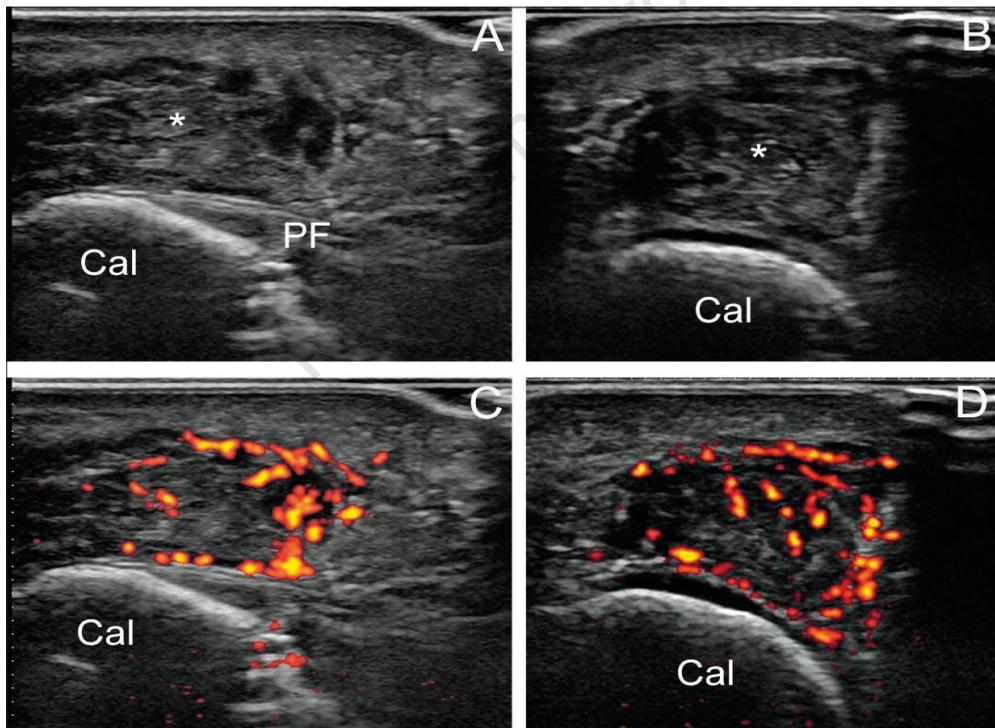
Sonogram of the subcalcaneal bursitis in the left plantar heel (Case 2). The long axis (A) and short axis (B) gray-scale sonograms show a well-demarcated predominantly hypoechoic and partially anechoic mass within the plantar fat pad. The long axis (C) and short axis (D) power Doppler sonograms show moderate hyperemia at the margin and inside of the lesion. Cal, calcaneus; PF, plantar fascia.
